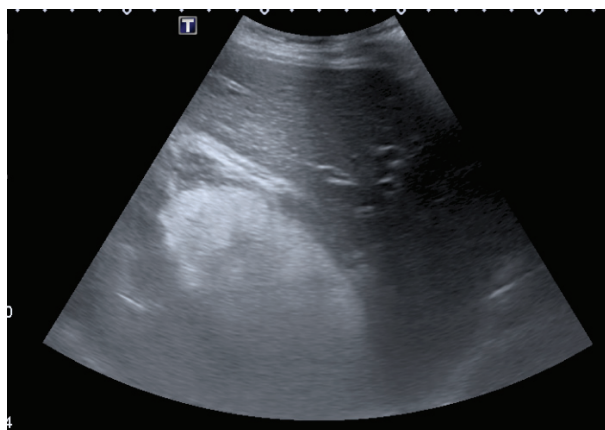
Abdominal ultrasonography which shows a hyper-echoic mass in the right renal region
